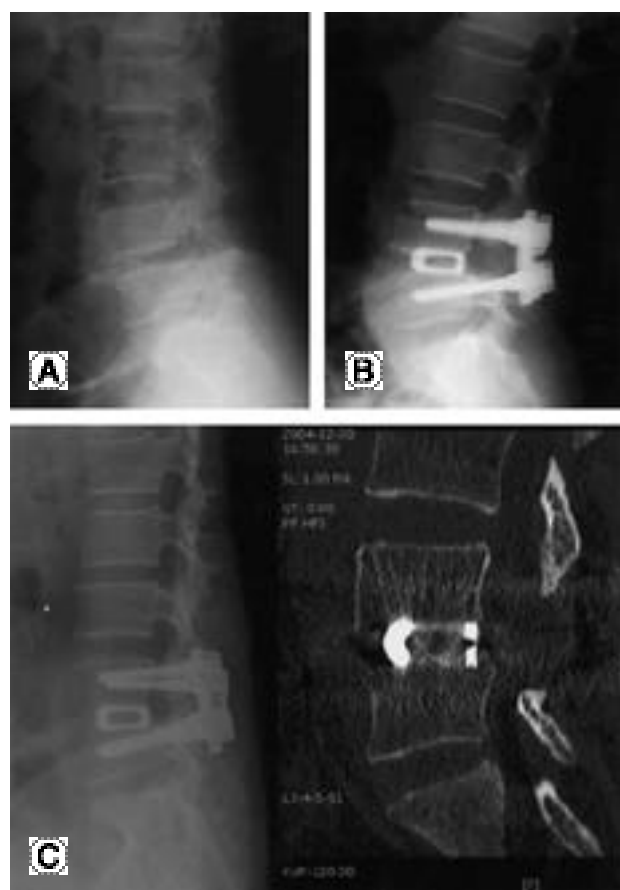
(A) Preoperative lateral radiographs of 46-year-old female shows grade II isthmic spondylolisthesis at L4-5 level. (B) Postoperative lateral radiographs shows the reduction of spondylolisthesis (33% → 13%). (C) Radiograph and CT scan at 26 months follow up examination shows maintenance of reduction with solid bony union.
